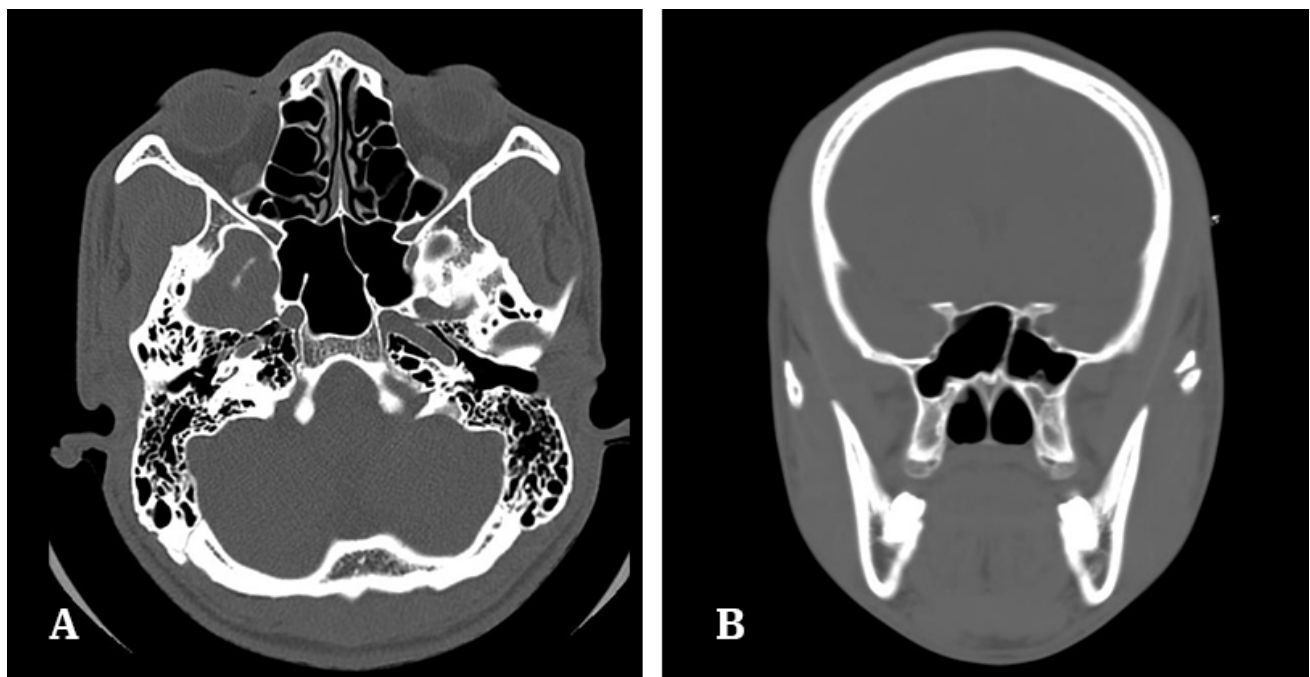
Axial CT images showing the sphenoid sinus septa attaching on: A: ICA canal bilaterally. B: left optic canal.
